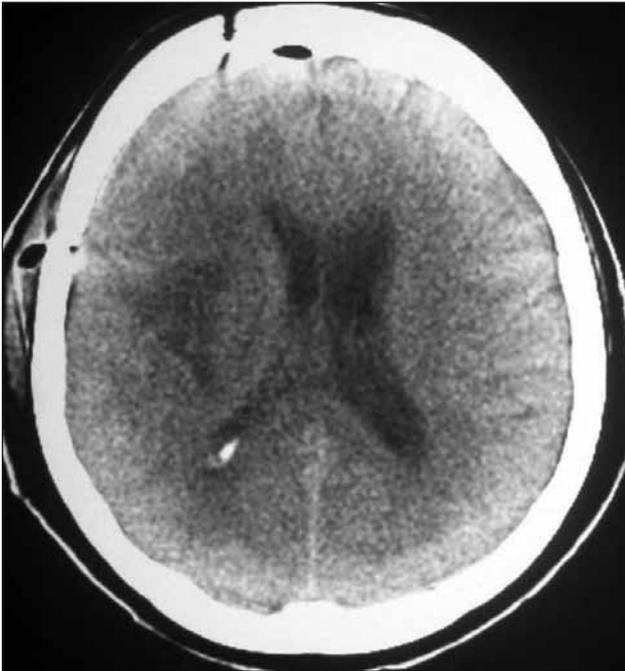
Postoperative CT scan showing right insular ischemia.
